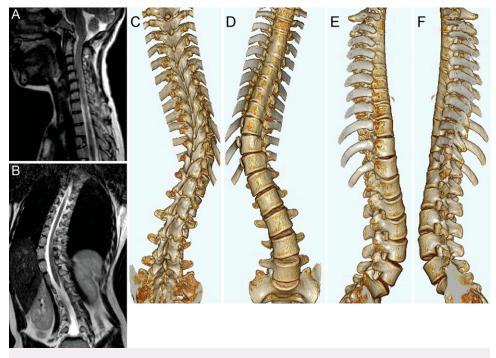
MRI and CT scan analysis. Cranial (A) and abdominal (B) MRI scans negated the presence of any myelopathies such as tumor, Chiari malformation, syrinx, low-lying conus medullaris, tethered spinal cord, or the like. CT scan-derived three-dimensional representation of the spine from the posterior (C), anterior (D), and lateral left (E) and right (F) perspectives revealed no apparent vertebral column abnormalities other than scoliosis.
